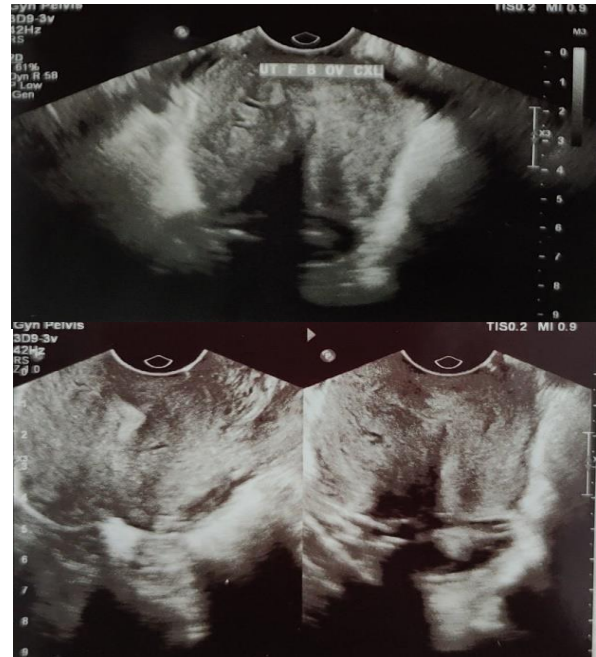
Ultrasound TVS with F/S/O deformed uterine fundus and non-visualisation of cervix s/o uterine inversion.
